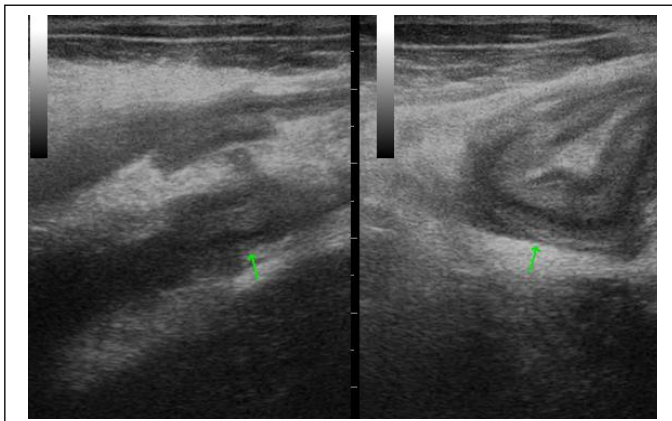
Transabdominal sonography of patient shows marked circumferential thickening of ceacum and ascending colon with preservation of gut signature.
